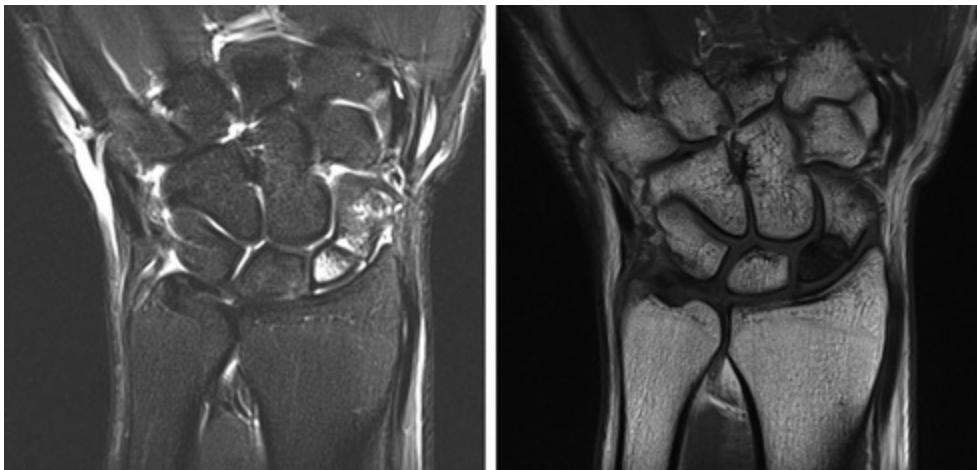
Magnetic resonance image of scaphoid nonunion with signal changes on t1 and t2 consistent with avascular necrosis of the proximal pole
